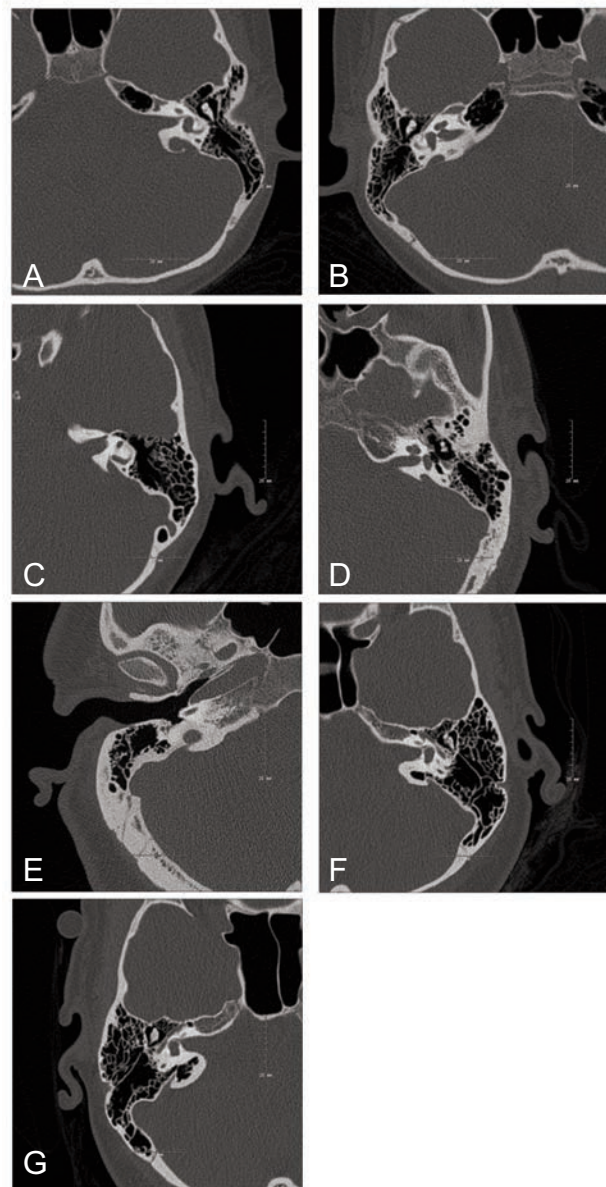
Axial computed tomography images showing EVA in A) case A left; B) case A right; C) case B; D) case C; E) case D; F) case E left; and G) case E right.
